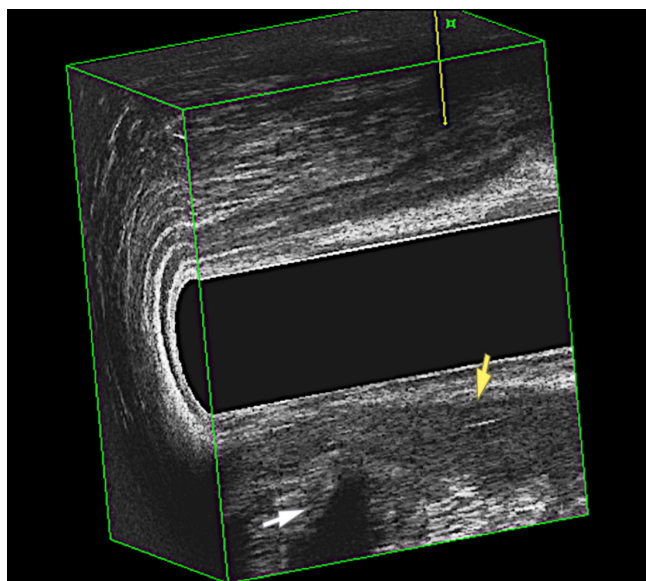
The 3-dimensional endoanal ultrasound image in the sagittal plane of a posterior transsphincteric fistula (white arrow) with a secondary tract extending into the supralevator space (yellow arrow) via the intersphincteric route. This fistula was categorized as grade 3C by the new classification.
